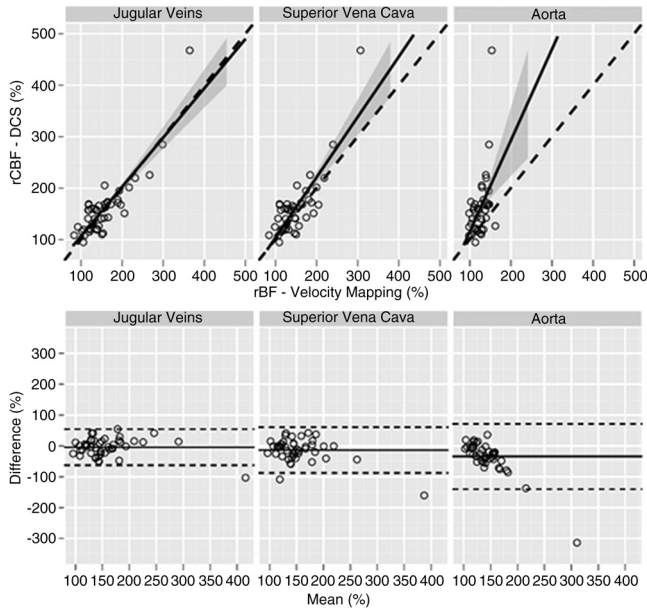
(Top) Changes in blood flow (rBF) measured with velocity mapping MRI in the jugular veins (left), superior vena cava (middle), and aorta (right) compared to $rCBF_{DCS}$. The solid line represents the best-fit line to the data, while the dashed line indicates the line of perfect concordance. The grey ribbon denotes the 95% confidence interval for the mean $rCBF_{DCS}$. (Bottom) Bland-Altman plots of the difference in rBF, measured with VENC-MRI, and rCBF, measured with DCS, versus the mean of these parameters. Solid horizontal lines indicate the mean difference between each VENC parameter and rCBF measured with DCS, while the dotted lines indicate the 95% limits of agreement.
